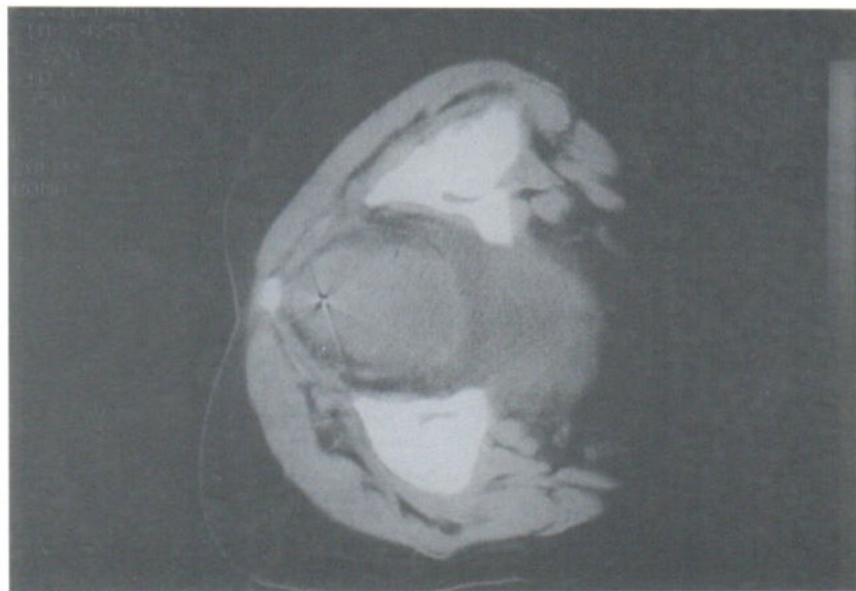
Left lateral decubitus CT scan of lower pelvis demonstrates 16-G trocar needle in the rectum at the level of the abscess.
